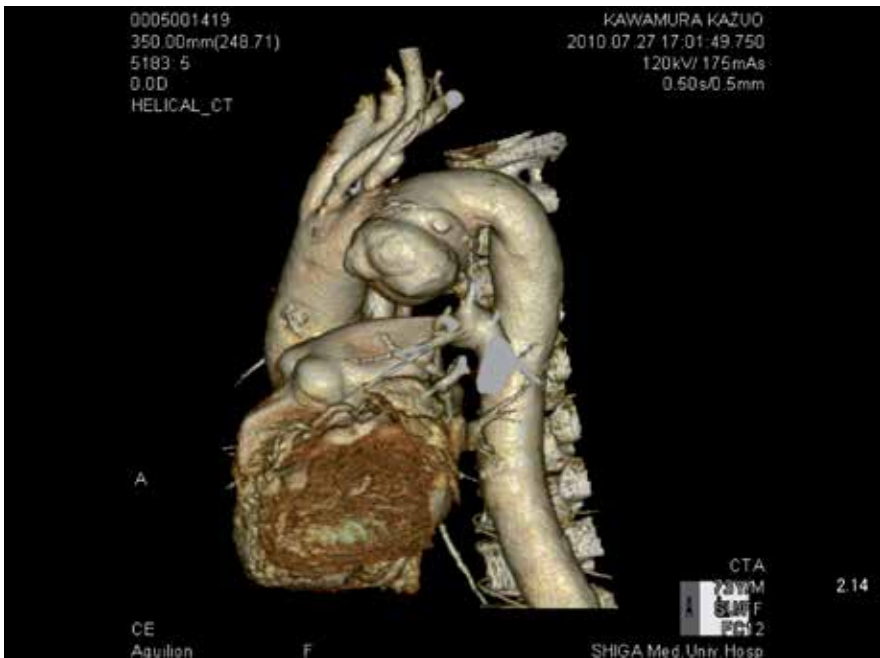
CT finding of distal arch aneurysm of thoracic aorta
